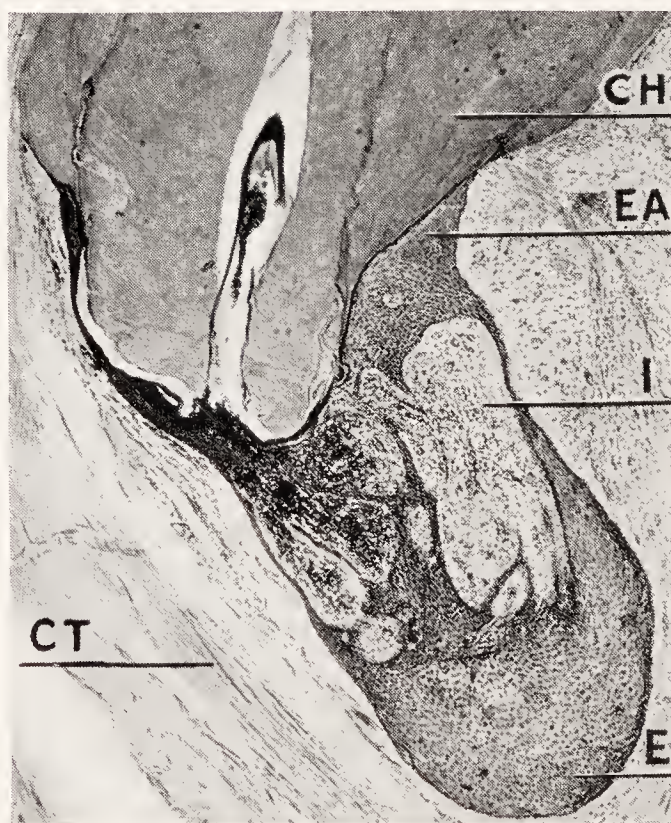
Root end of an upper bicuspid with decomposed pulp. Solid mass of epithelium present in the apical granuloma. *E*, epithelial proliferations at and near the root end; *EA*, epithelial attachment to the root surface; *CH*, cementum hyperplasia above the epithelial attachment; *I*, round cell infiltration in the connective tissue between the epithelial strands; *CT*, connective tissue capsule. (Gottlieb, Jour. Am. Dent. Assn.)
